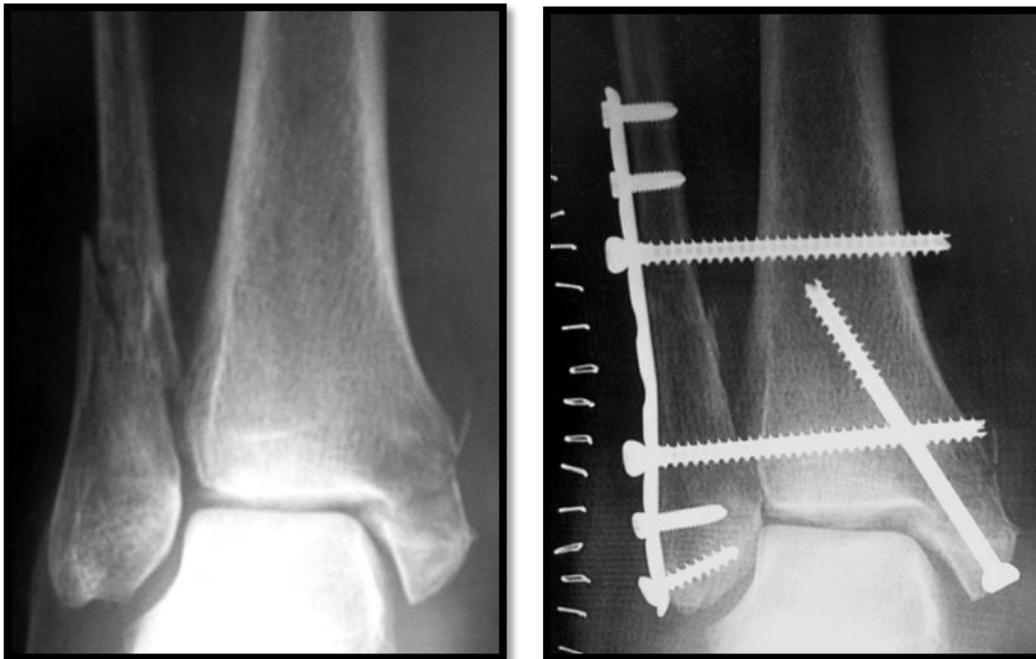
Initial and 12 week radiographs of a bimalleolar ankle fracture in a complicated diabetic.
